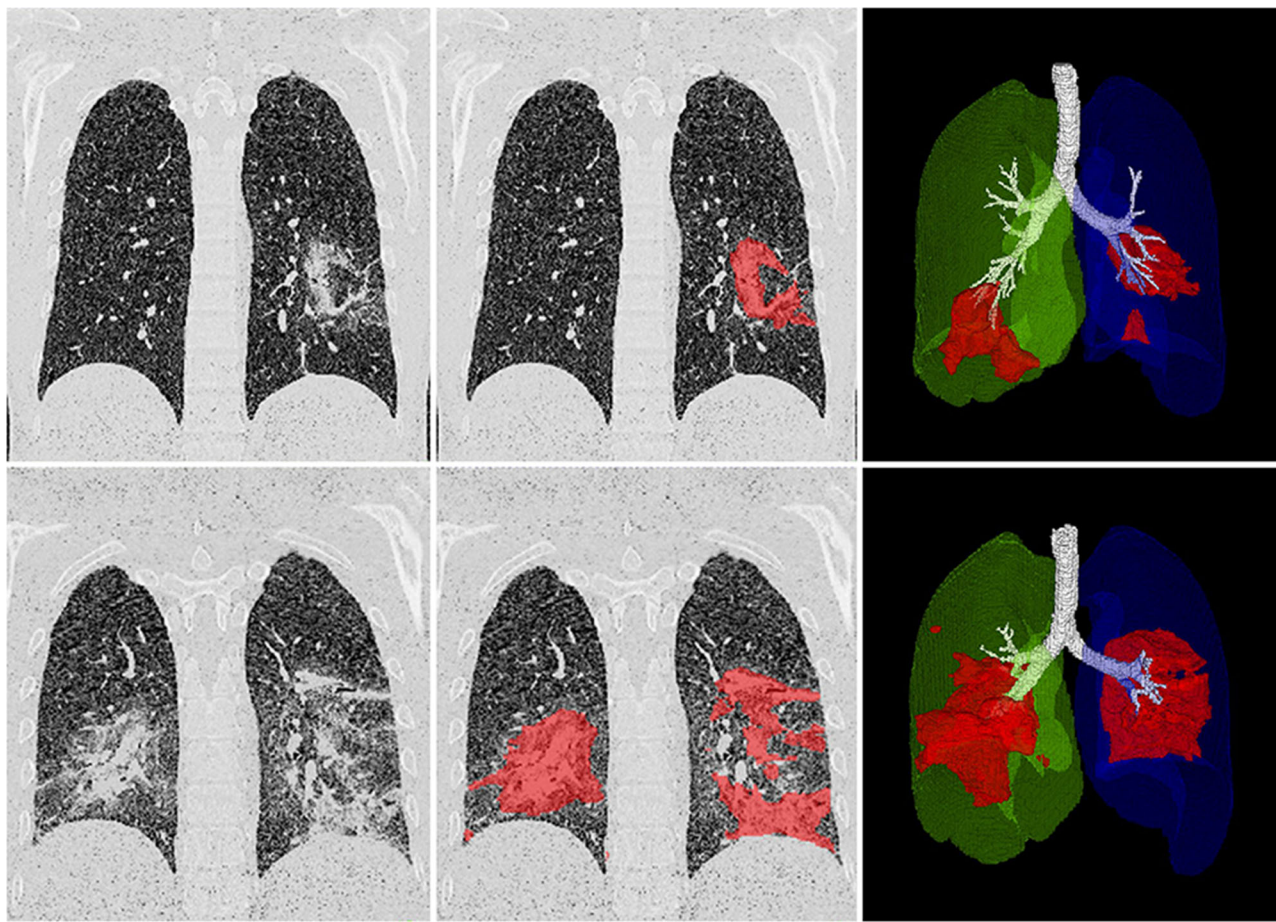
A coronavirus disease 2019 (COVID-19) patient with disease progression. Upper and lower rows show initial and follow-up computed tomography (CT) with standard coronal image, coronal image with color covering the lesions, and 3D surface rendering image. A regional lesion is observed in the dorsal segment of left lower lobe. Both consolidation and ground-glass opacity are automatically detected and labeled with red. The disease progress rapidly with a large area of consolidation in bilateral lower lobes observed. The lesion size in 3D image seems to be larger than that in coronal image.
